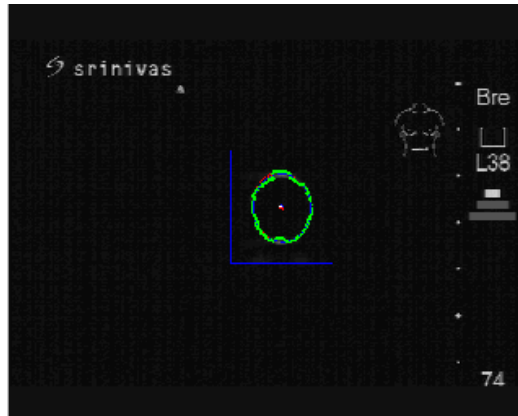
A small Region of Interest (ROI) (blue rectangle) is applied around the target area to reduce the computing load. The ultrasound image system is SonaSite180 with a 7.5MHz image probe (Sonosite, FUJIFILM SonaSite, Inc.).
